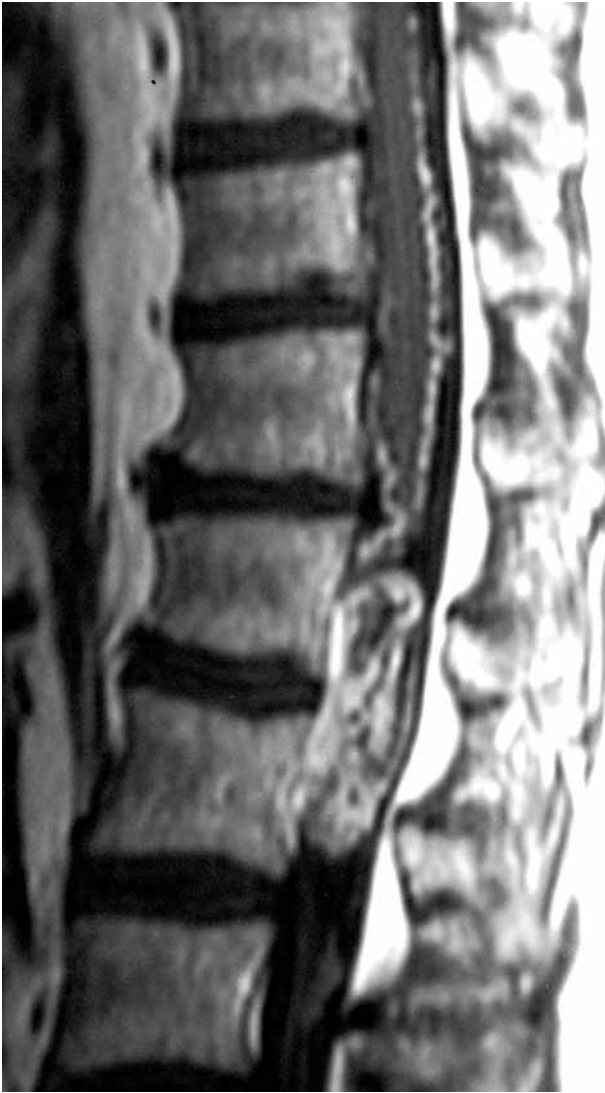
Contrast-enhanced sagittal T1-weighted MR image of the thoracolumbar junction of the spine showing a heterogeneous hyperintense lesion occupying the vertebral canal below the conus medullaris.
